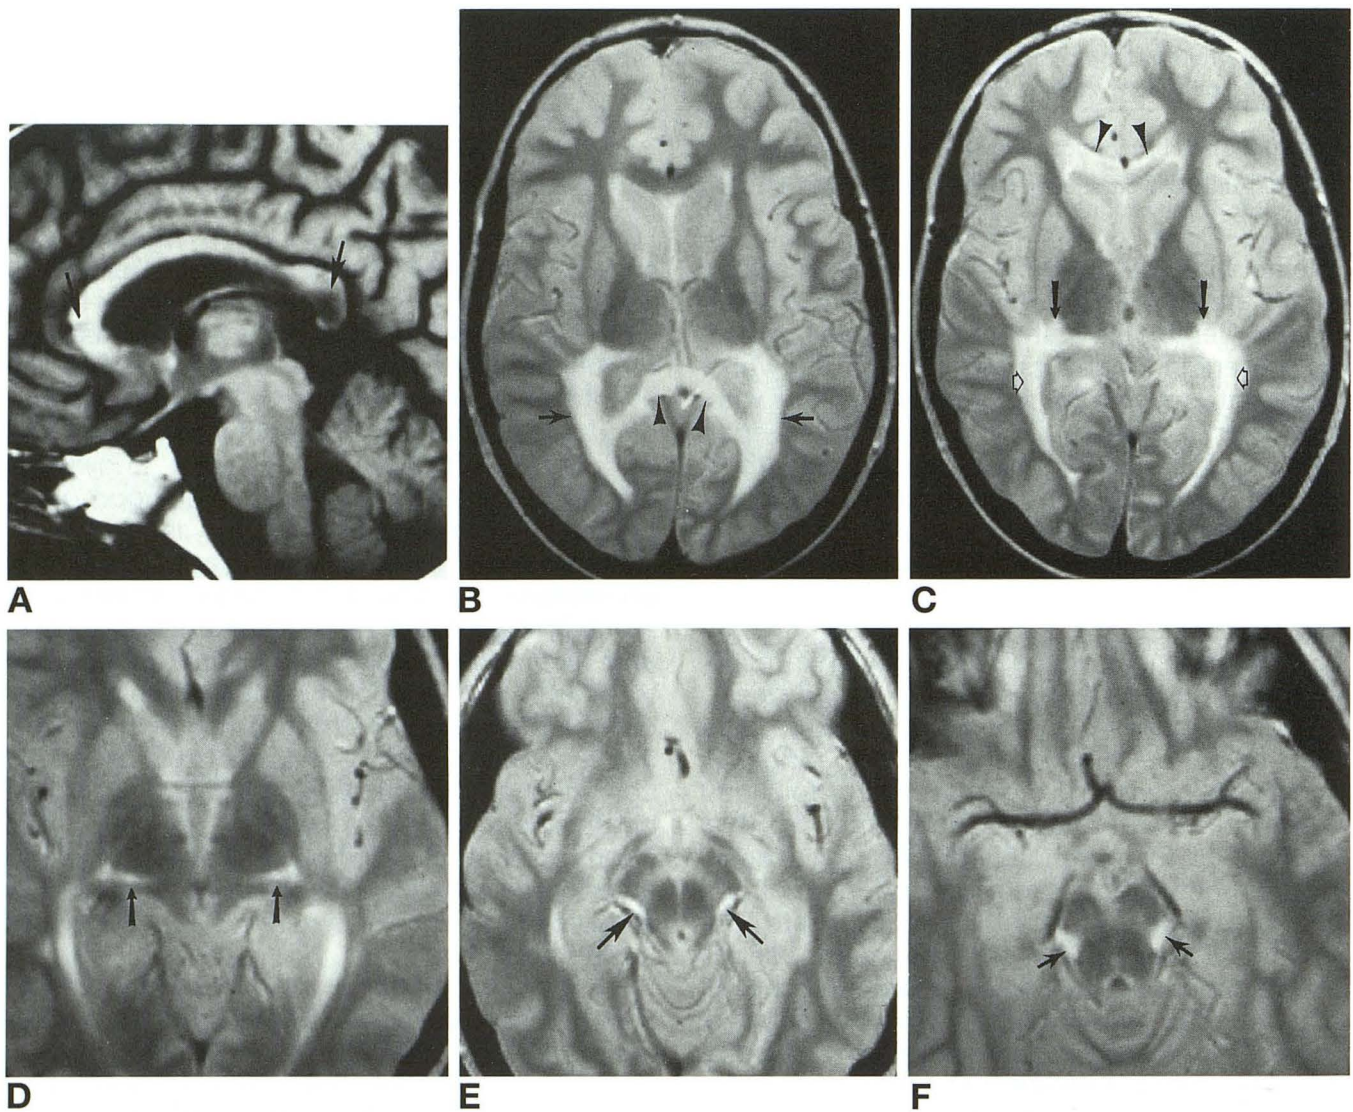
MR images in a 9-year-old boy with a parietal pattern of adrenoleukodystrophy.
